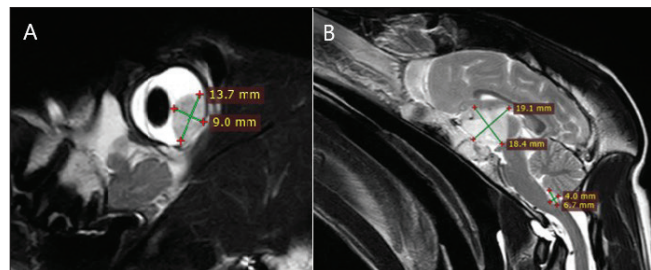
Contrast-enhanced brain MRI evaluation. A. Intraocular mass on T2-weighted sagittal plane in left bulbus oculi at the size of 13.7 x 9.0 mm, B. Solid masses on the T2-weighted sagittal plane at the suprasellar cistern, third ventricle and chiasma opticum levels of the brain (19.1 x 18.4 mm) and in the medulla oblongata adjacent to the caudal cranial fossa (4.0 x 6.7 mm)
